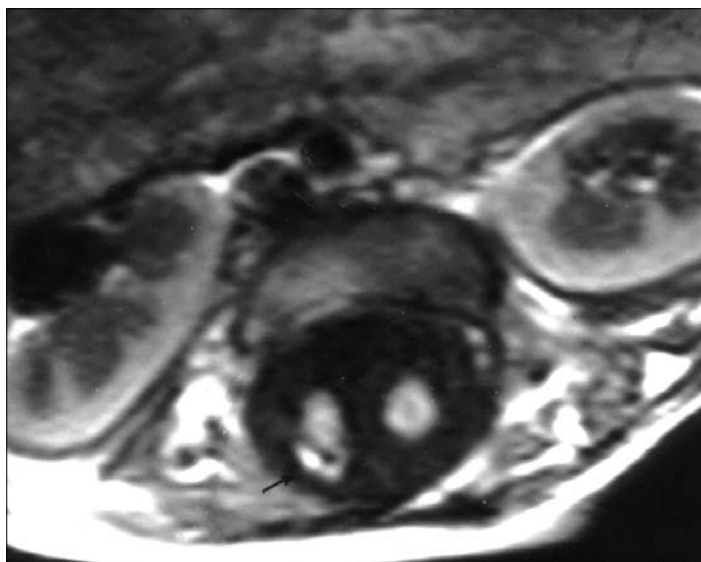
Transverse precontrast T1 weighted MR image demonstrates the two hemicords and a lipoma (*arrow*) in the right hemicord.
